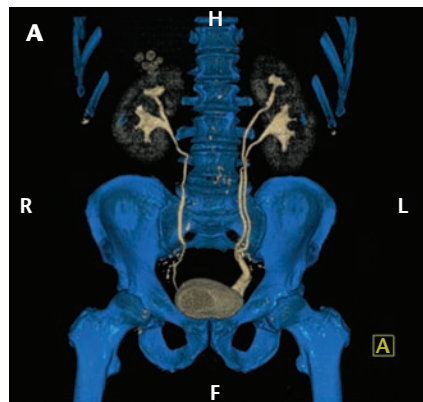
Three-dimensional volume rendered (A) and maximum intensity projection images obtained from the computed tomography urogram. The images showed partial duplication of the right pelvicalyceal system with a single right ureter and complete duplication of the left pelvicalyceal system with 2 left ureters (A). The lower pole left ureter is of normal course and caliber and enters the bladder orthotopically. There is fusiform dilatation of the distal portion of the upper pole left ureter as it terminates in the prostatic urethra (B).
